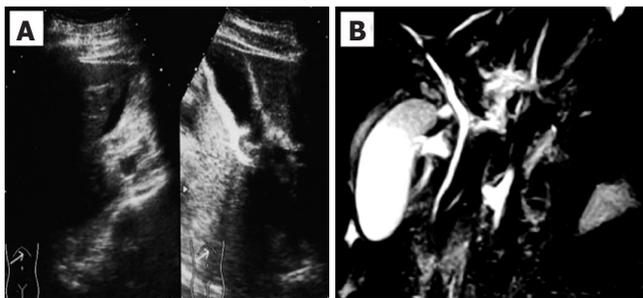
A: Abdominal ultrasonography (US) revealed a marked gall bladder swelling and wall thickness without stones or debris, indicating an acute cholecystitis; B: Magnetic resonance cholangiopancreatography (MRCP) revealed a similar gall bladder thickness as well as free space around the gall bladder, suggesting exudate associated with severe inflammation.
